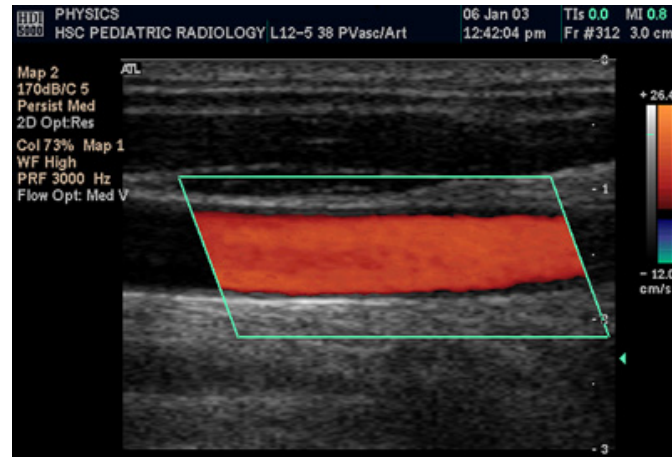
Colour Doppler Scan of the Common Carotid Artery. [3]
